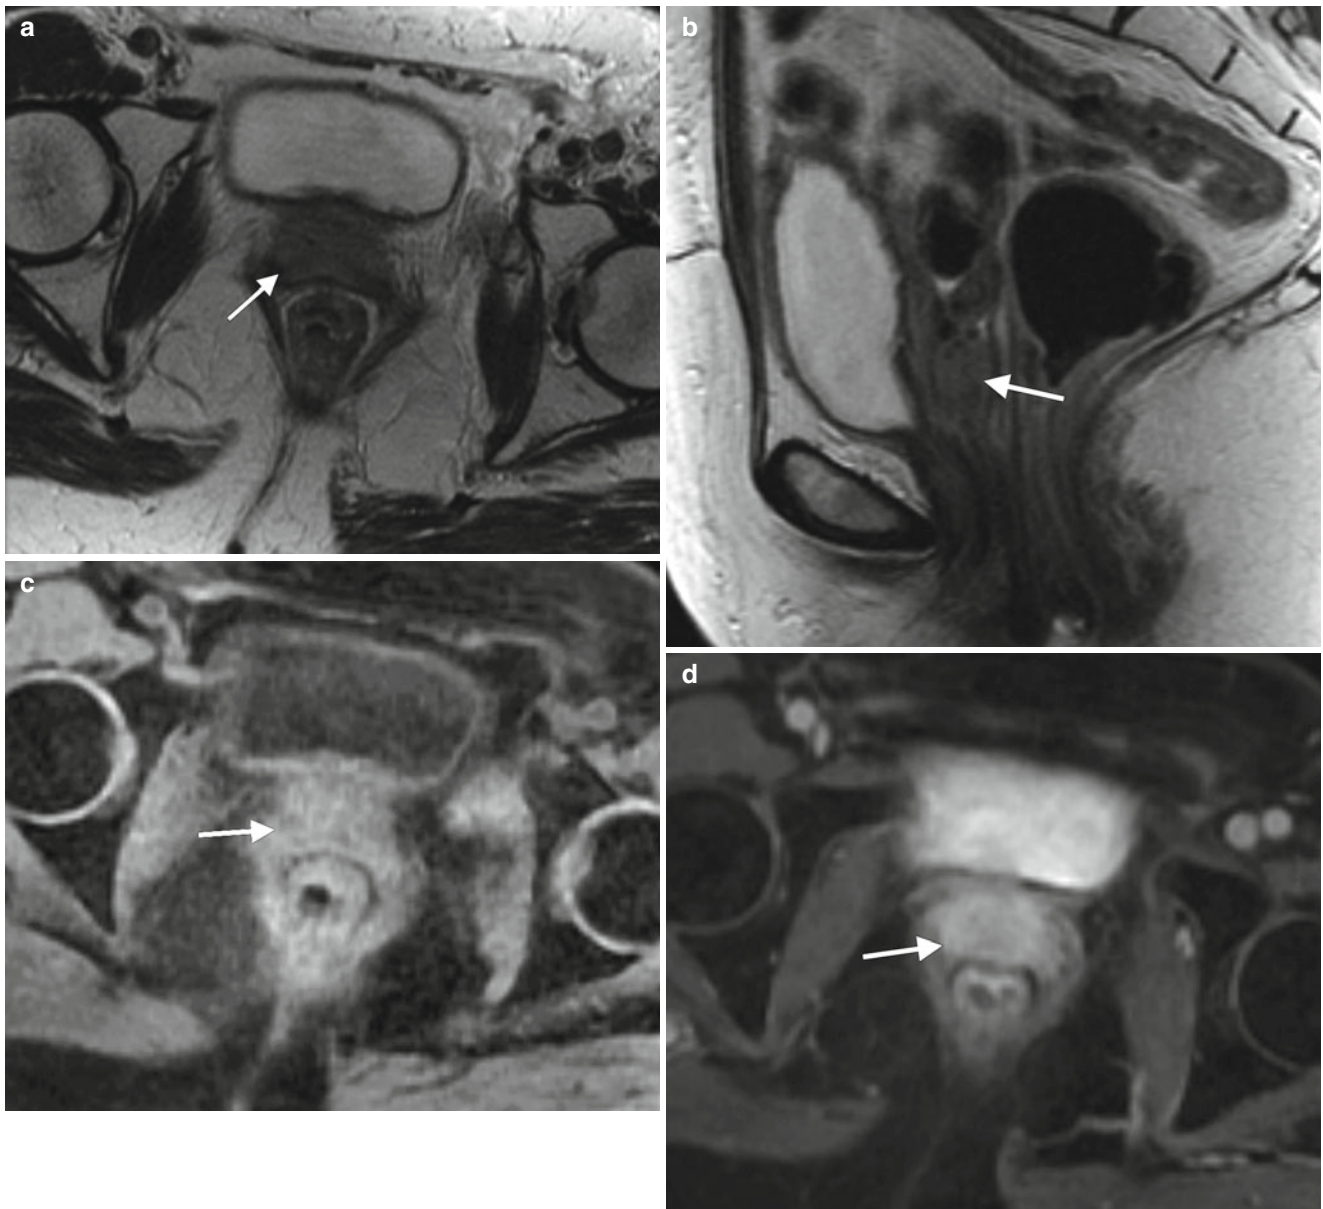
This 59-year-old woman had a history of stage IIIC endometrioid adenocarcinoma of the endometrium, treated with radical hysterectomy and bilateral salpingo-oophorectomy 9 months earlier. Axial (a) and sagittal (b) T2-weighted MR images and axial, fat-suppressed
